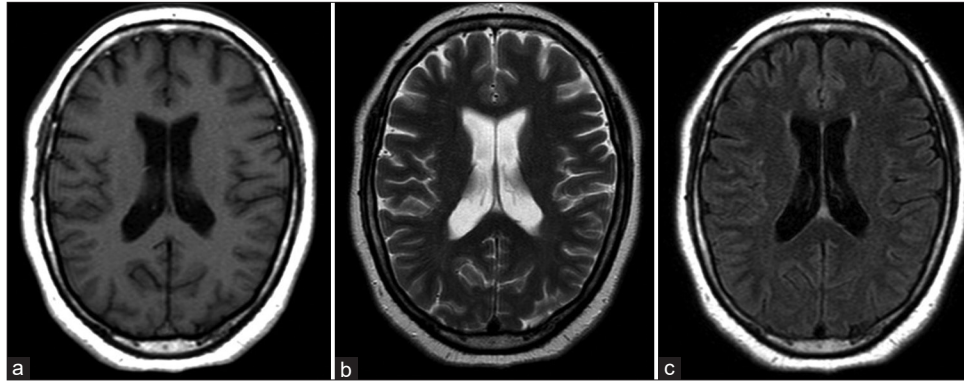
T1-weighted (a), T2-weighted (b), and fluid-attenuated inversion recovery (c) magnetic resonance imaging at the age of 53 show no abnormalities in the brain parenchyma.
